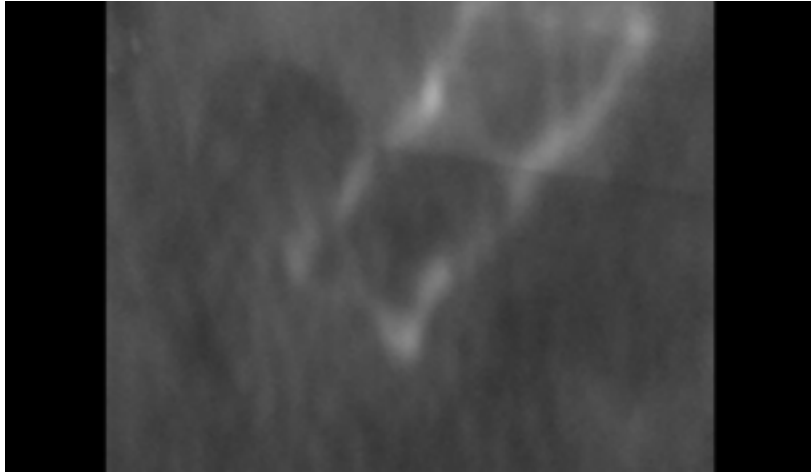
2D CT: sagittal reconstruction; spicule of 1 mm from the tip, not visible on X-ray
